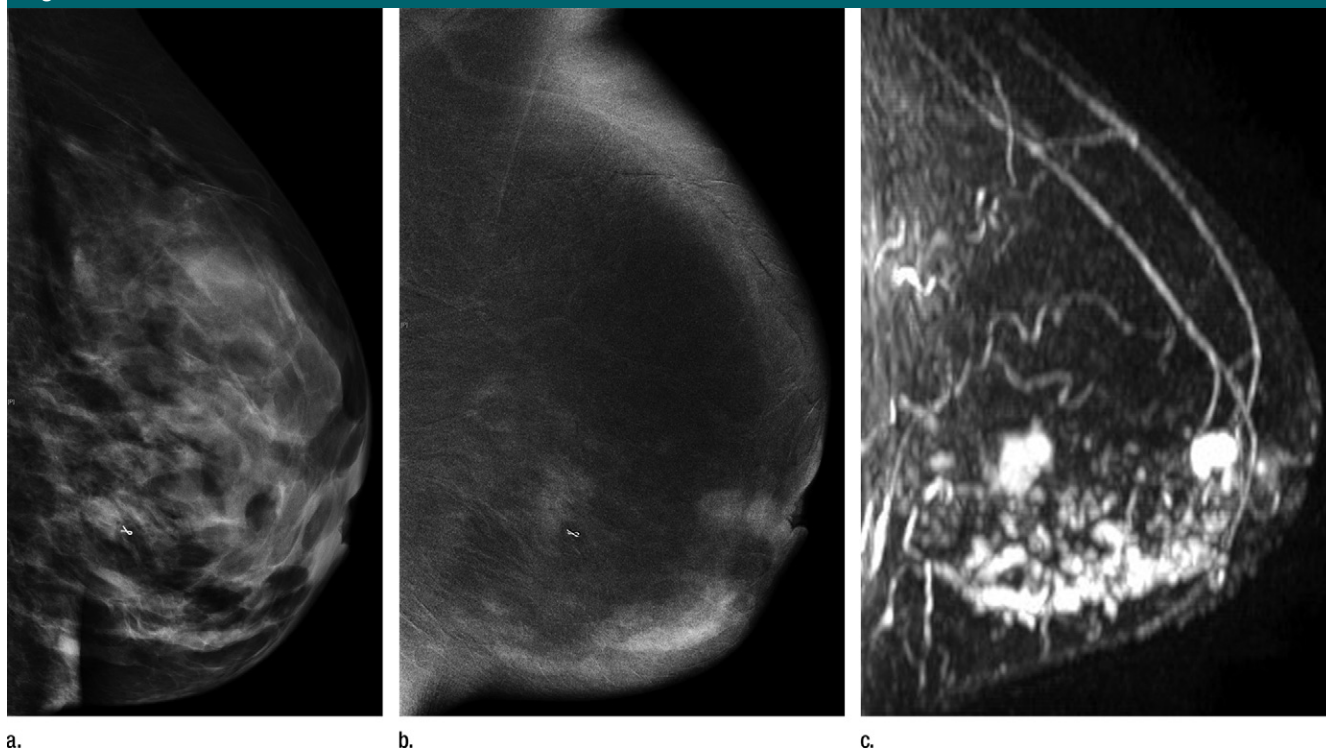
Images in 39-year-old woman with infiltrating ductal carcinoma and extensive DCIS who presented with left breast pain and nipple retraction. (a) Left mediolateral oblique conventional digital mammographic image shows dense breast tissue. Left (b) mediolateral oblique DE CE mammographic and (c) sagittal subtraction MR images show multicentric disease. Marker clip can be seen on a and b.
